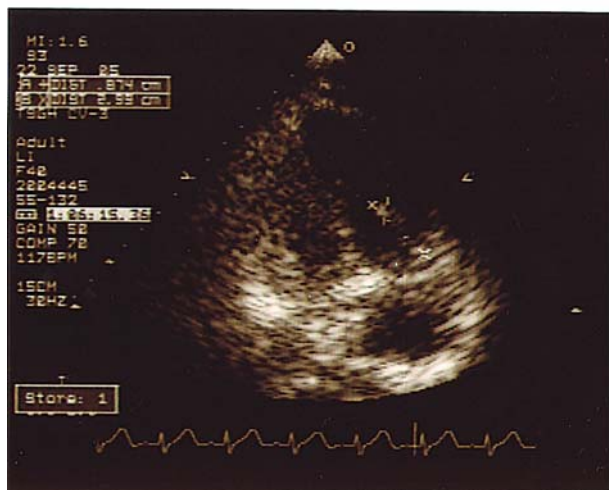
Echocardiography revealed one vegetation (0.8×3.0 cm²) on the tricuspid valve with severe tricuspid regurgitation.
